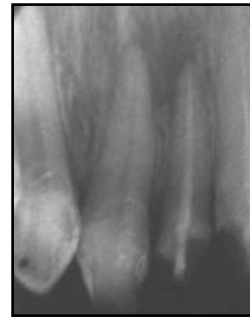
Radiographic image of 22, 6 months after MTA treatment
